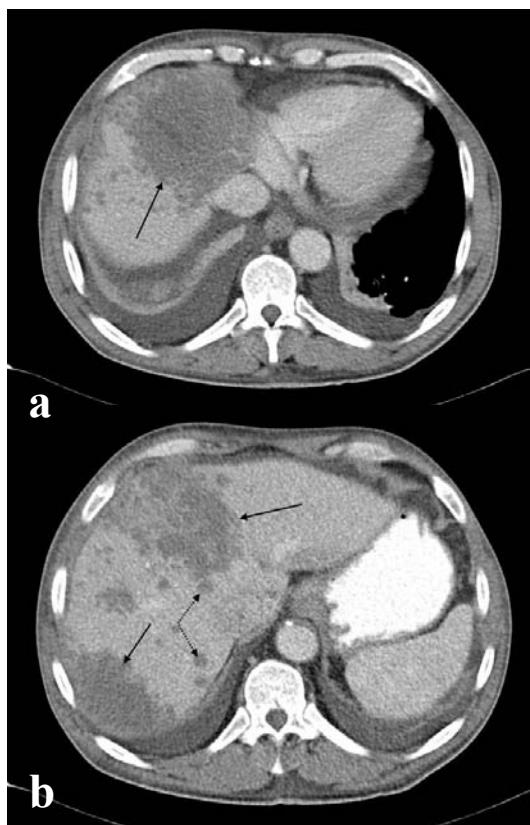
CT scan before PEG IFN treatment. 2a: Hypodense focus in S8 with diameter of 96mm (solid arrow), 2b: focuses in segments 4 and 6 with diameter of 90 mm and 85 mm respectively (solid arrow). Secondary smaller focuses are also visible (dashed arrow).
